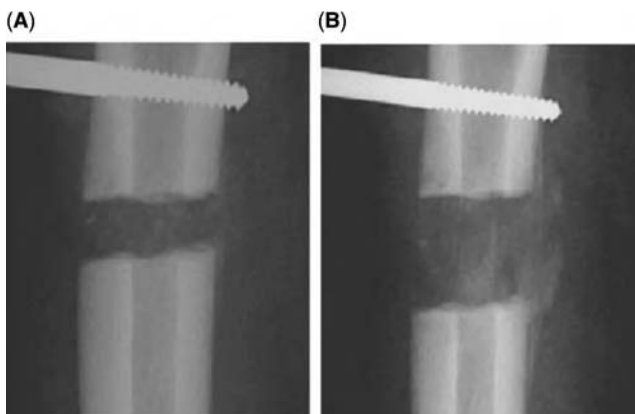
Radiographs of the right femur of a case before the first transplantation of MSCs (A) and two weeks later after transplantation (B). Callus formation was enhanced within the distracted area. Source: From Ref. 12.
